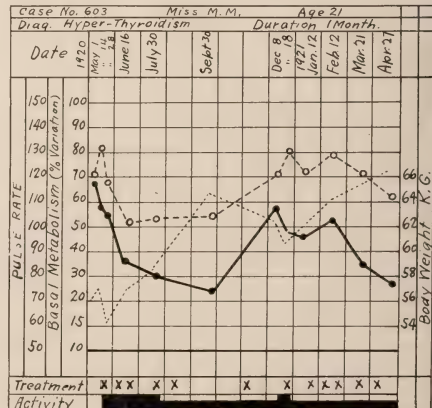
Figure IV—Case No. 603. Exophthalmic goiter. Graphic chart showing change occurring in the basal metabolic rate and pulse. X-ray treatment indicated at the bottom by a cross.
